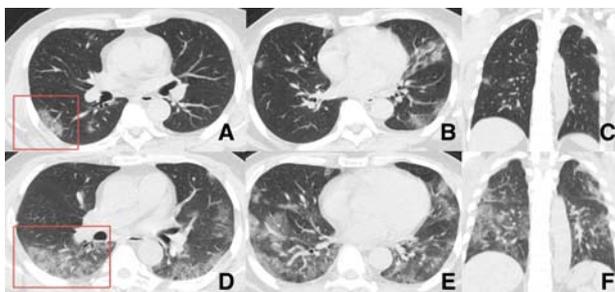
CT images of a 50-year-old man with COVID-19. Initial scan on day 6 after initiation of symptoms (A, B, C) showed peripheral GGO (red box) with the progression of the same on follow up scan (D, E, F) when patients symptoms worsened.
